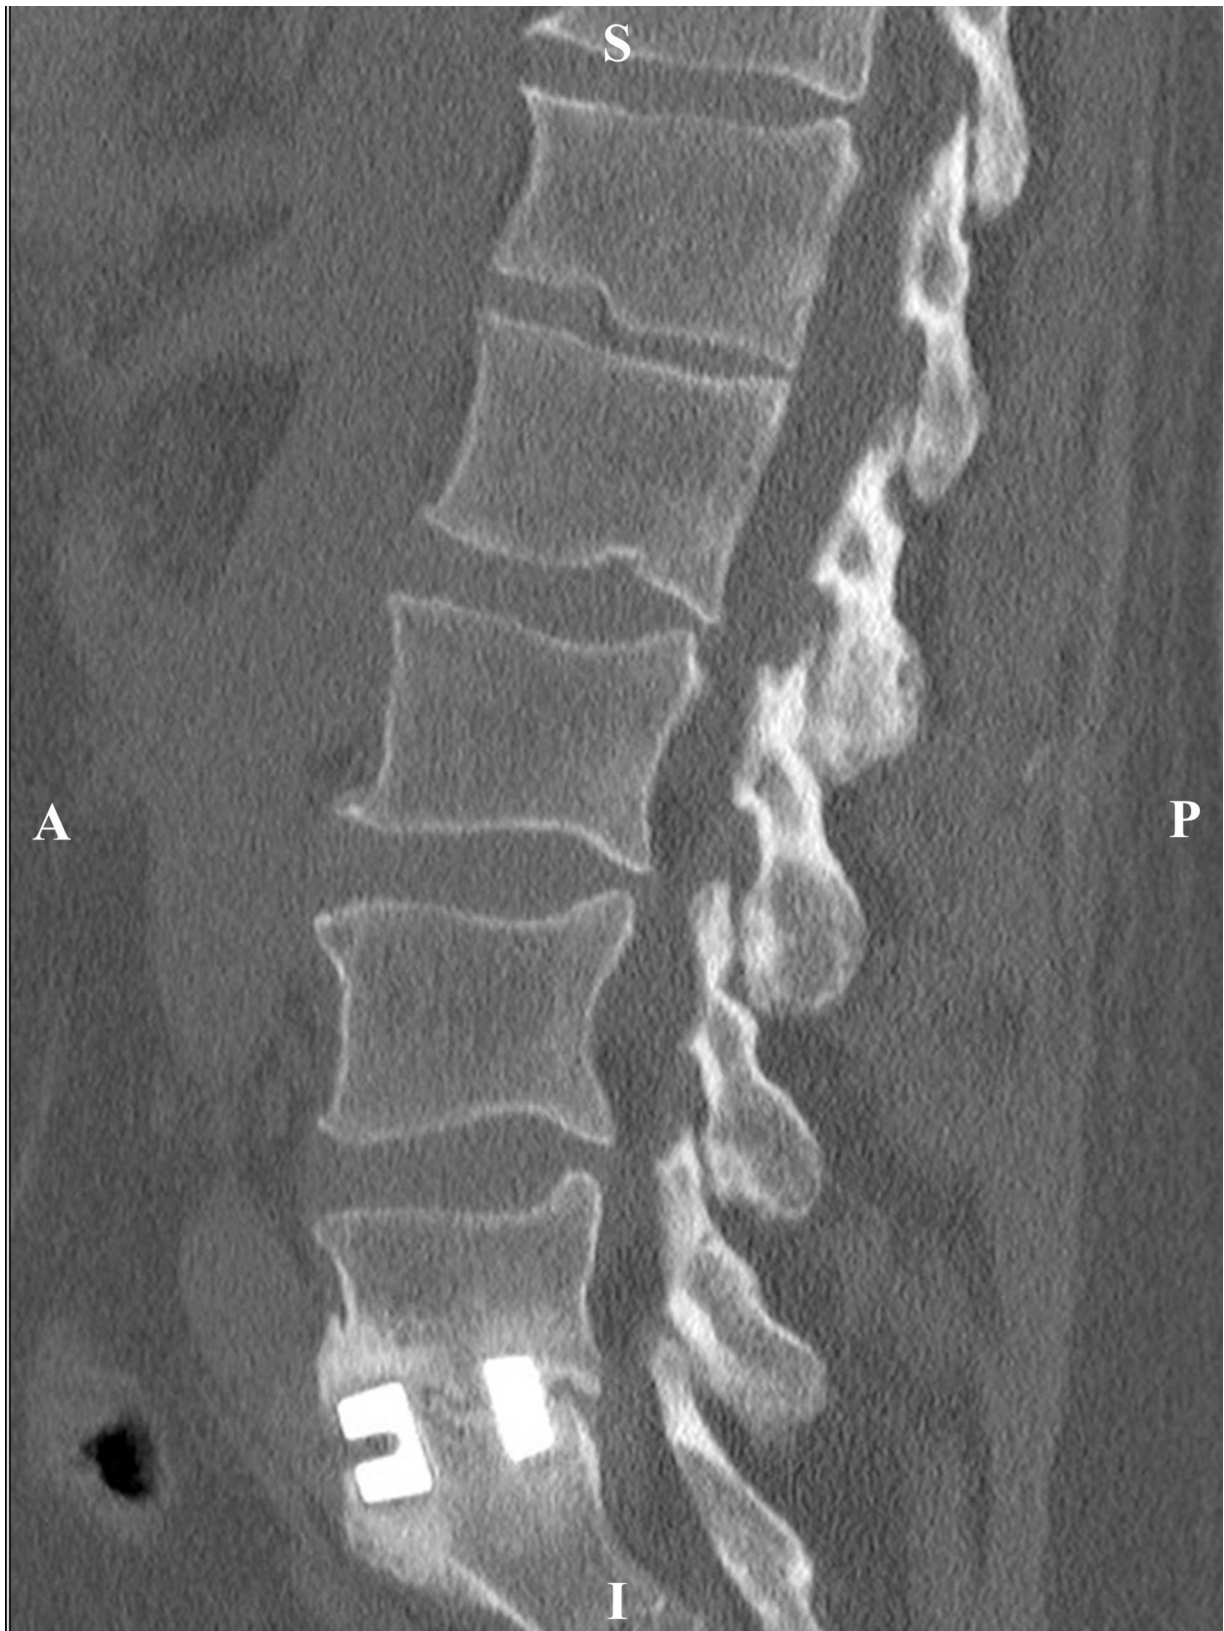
Case 1: Contrasted nine-month post-op CT image showed successful fusion without migration of the Si_3N_4 interbody spacer.
